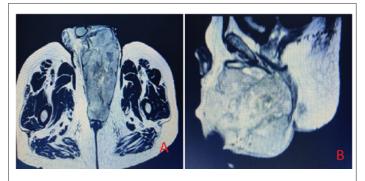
MRI of Abdomen and pelvis : A: Axial, B: Sagittal T2weighted images demonstrate a T2-hyperintense soft tissue mass in the perineum with loss of fat plane between the lesion and anterior wall of the rectum.
